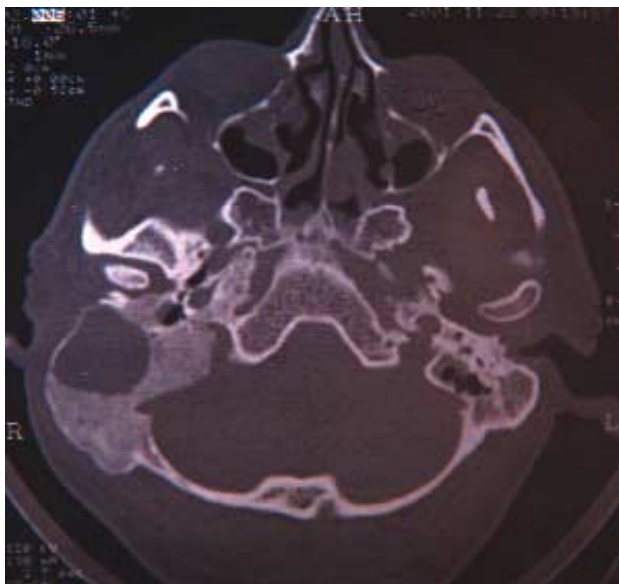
A computed tomographic scan showing sclerosis, the marked focal expansion of the right squamous temporal bone, and the partial expansion of the occipital bone, as well sclerosis and a small focal expansion consistent with fibrous dysplasia in the left temporal bone.
